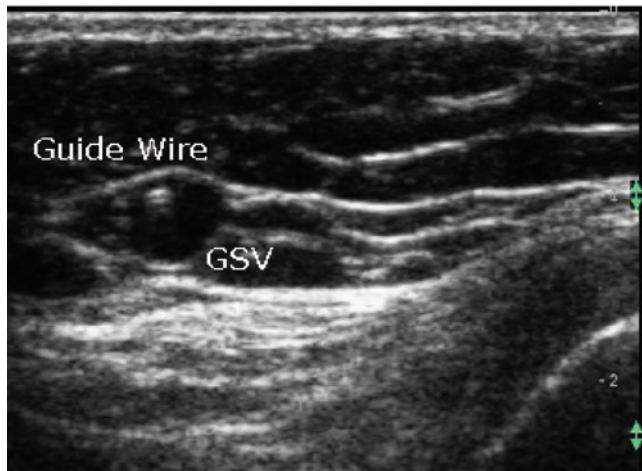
Position of the guidewire and radiofrequency catheter is monitored by ultrasound visualization. (Adapted from Pichot O, Atlas of Ultrasound Images, Copyright VNUS® Closure.)
